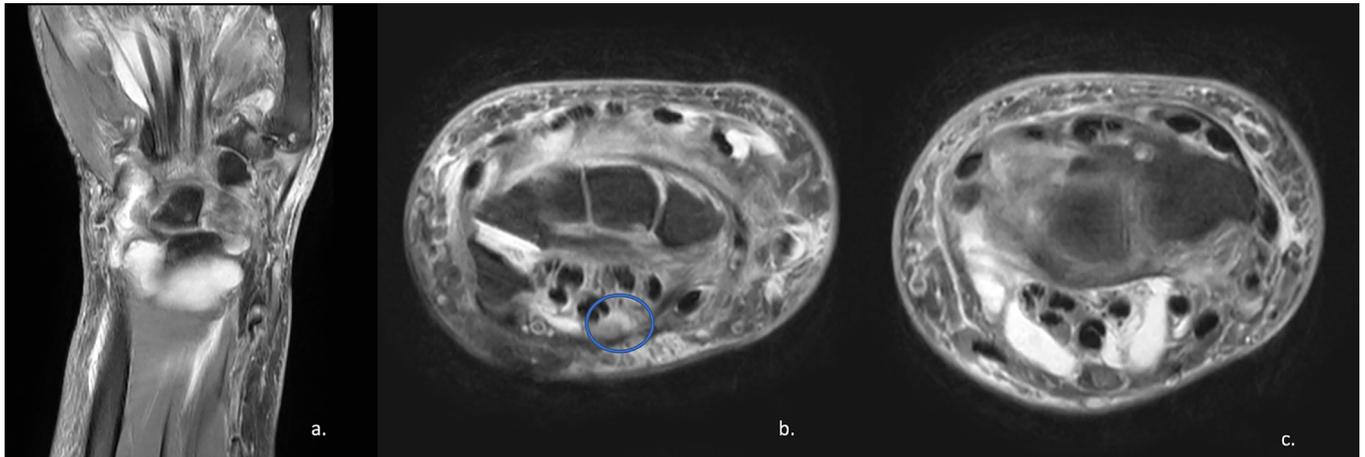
a. Coronal T2 MRI sequence of volar aspect of hand and wrist. b. Axial T2 MRI at level of carpal bones. Compressed median nerve is blue marked c. Axial T2 MRI sequence. Diffuse involvement around the flexor tendon.
